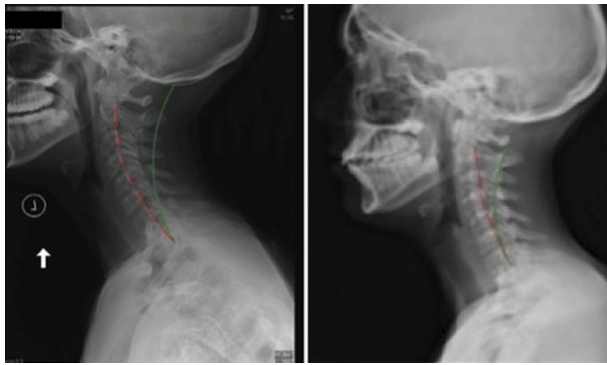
Cervical spine radiographs
